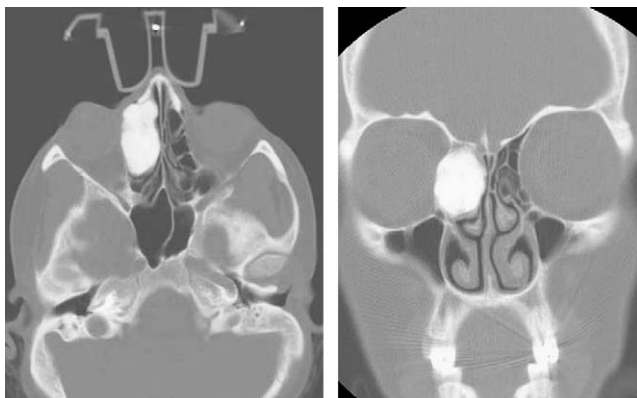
Axial and coronal sinus CT images of an ethmoid osteoma.
